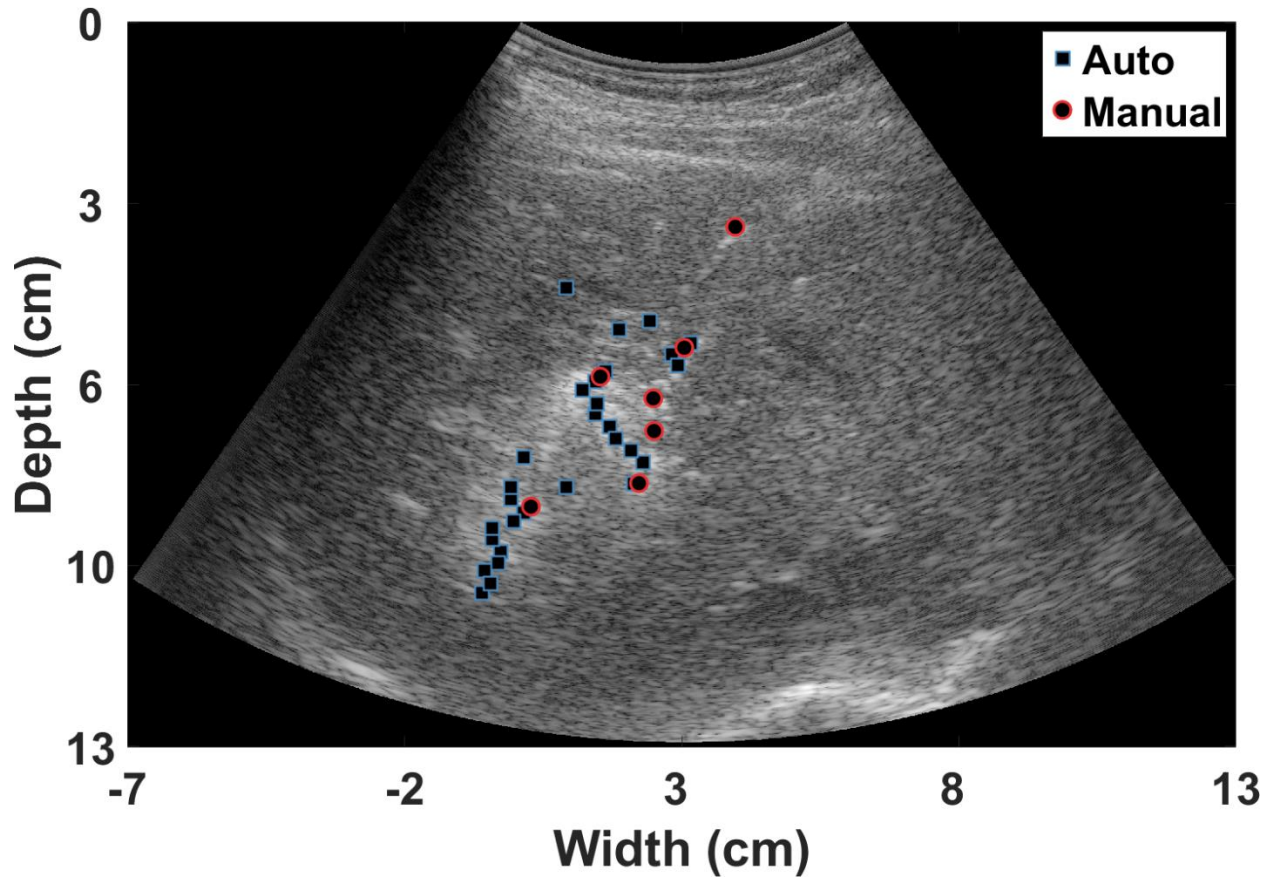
Example of automatic feature selection (blue squares) vs. manual feature selection (red circles) in ultrasound B-mode image.
